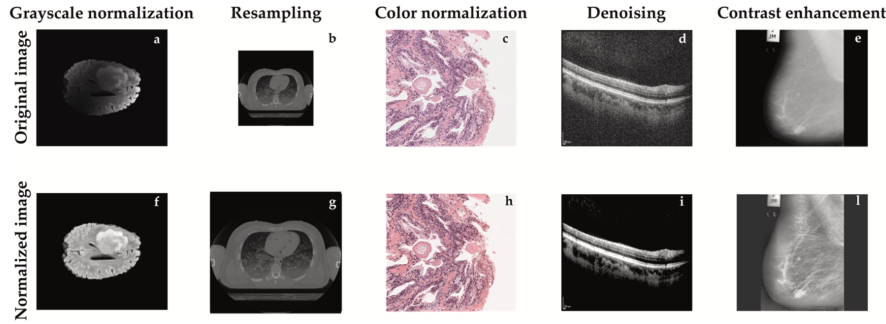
Examples of images resulting from data preparation approaches in healthcare: (a, f) grayscale normalization in MR, (b, g) resampling in CT, (c, h) color normalization in digital pathology, (d, i) noise reduction in OCT, (e, l) contrast enhancement in mammography. These images were collected by Seoni et al. [66].
